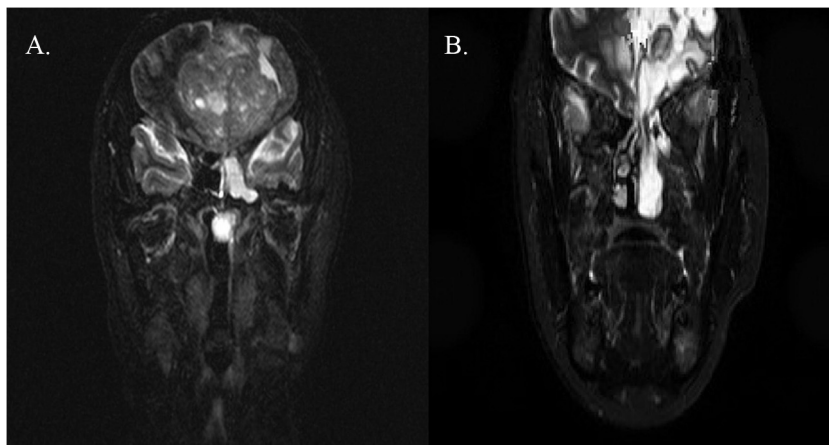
(A) Pre-craniotomy MR imaging. There was a huge left lobe meningioma ($6.1 \times 6.5 \times 6.3$ cm) associated with mass effect compressed on the frontal horn of the ventricle, with the development of a left side meningoencephalocele with defect of the left cribriform plate, caudally extending into the ethmoid and nasal cavities. (B) Follow-up MRI at 5 months after craniotomy for meningioma. Lobulated and pedunculated fluid accumulation within the left nasal cavity, and perifocal edema with some encephalomalacia was noted.
